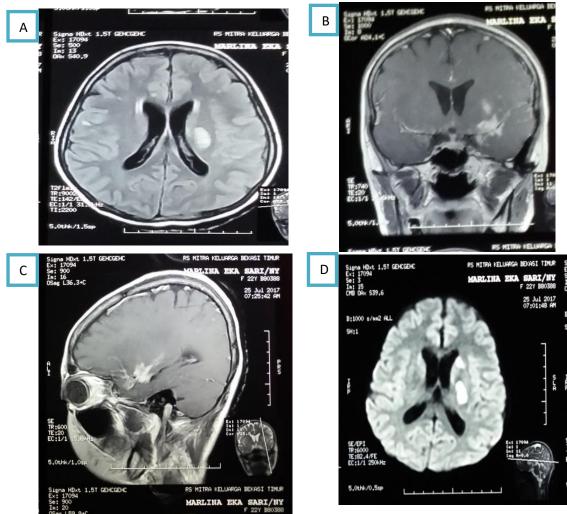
A-D MRI of the head with enhancement in the right basal ganglia
